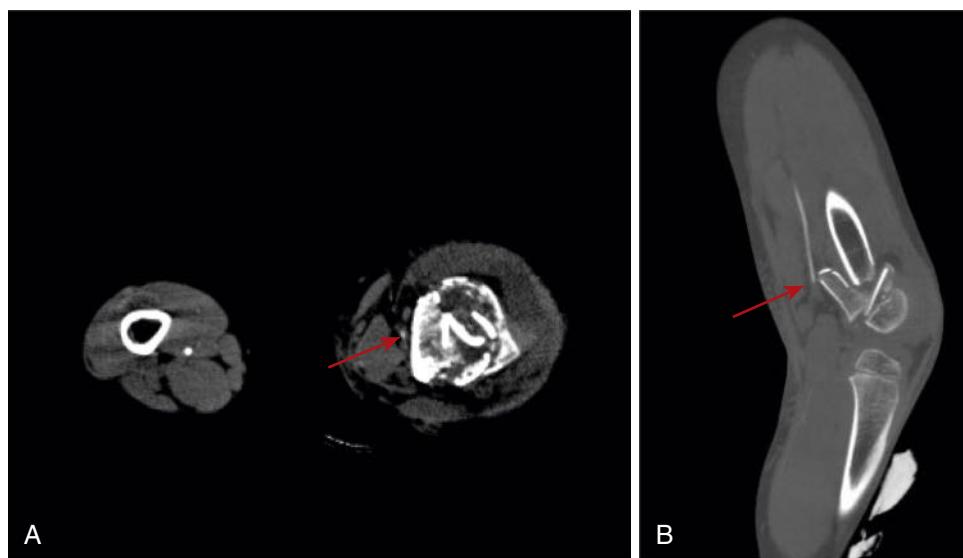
Computed tomographic angiography images from a patient sustaining blunt trauma to the left lower extremity with comminuted femur fracture. Note diminutive (likely spasm) left superficial femoral artery at the level of the fracture (A, arrow) just proximal to its abrupt truncation, seen best on reconstructed images (B, arrow).
